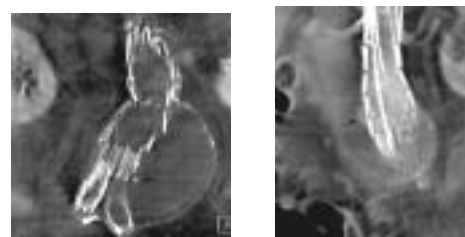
Flat-panel-CT (FP-CT) after endoluminal treatment of abdominal aortic aneurysm. a.) Non-enhanced FP-CT; coronal MPR: The relation of the stent-graft to the aneurysmal sack is nicely shown.
